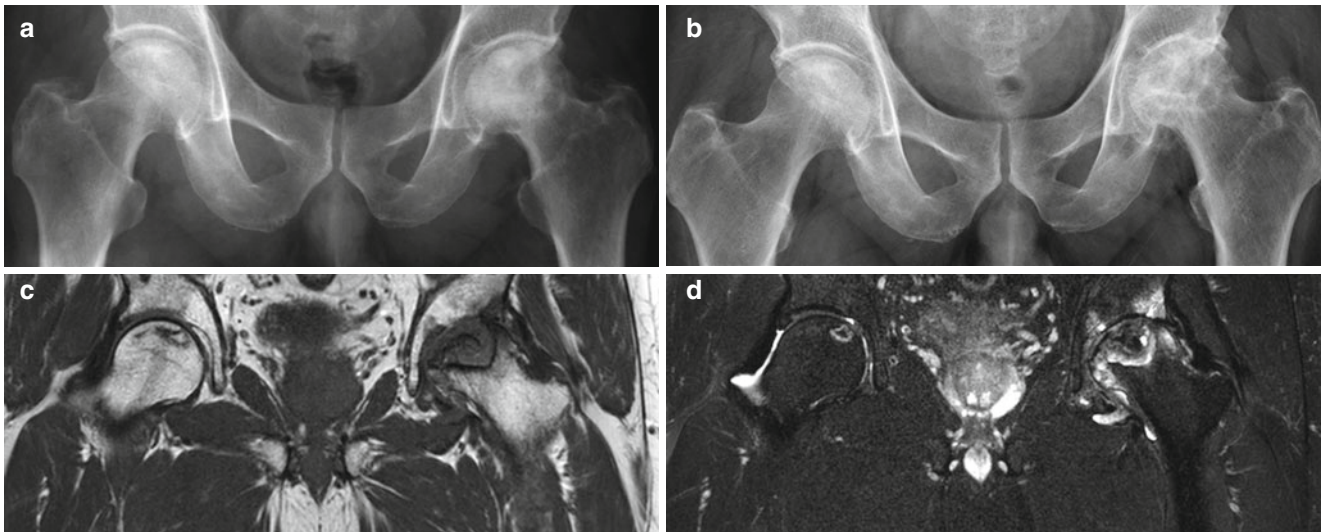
Intraosseous location of ON in a 54-year-old woman. (a) Plain radiograph of hip shows ON of both femoral heads. The right femoral head shows normal contour; however, the left femoral head shows subchondral collapse. (b) Six months later, the left femoral head shows progression of subchondral collapse. The right femoral head has
